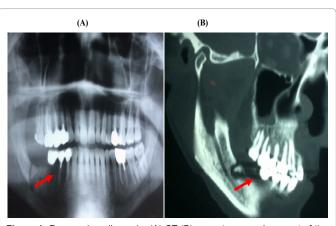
Panoramic radiography (A) CT (B): an osteonecrosis aspect of the left lower jaw with extensive osteolysis in the posterior region of the horizontal branch of the left maxillary bone and bone sequestrum (Arrow).
